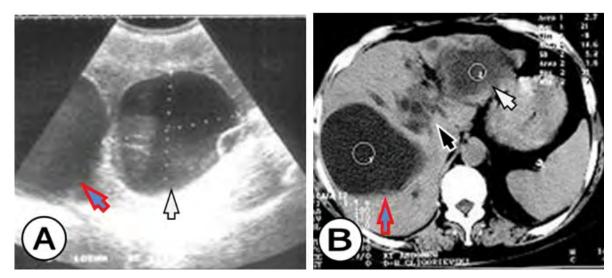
(A) The US of the liver visualized inflamed hydatid cysts (white arrow), (B) CT scan of the liver shows the inflamed hydatid cysts (white arrow), visualization of hydatid doter cysts into the biliary stem (black arrow) and a hydatid cyst with a diameter of 65-105 mm (red-blue arrow). An abdominal CT scan showed a cystic lesion in the left hepatic lobe, with a thickened wall and multiple thickened septae within, and, also, dilation of the intrahepatic bile ducts.
